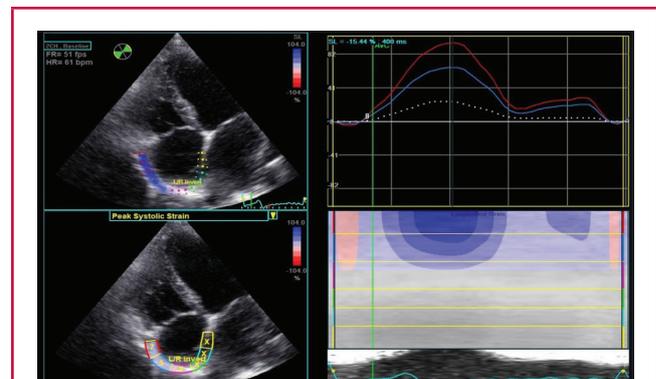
Two-dimensional speckle-tracking imaging in the apical two-chamber view: right atrial strain.
